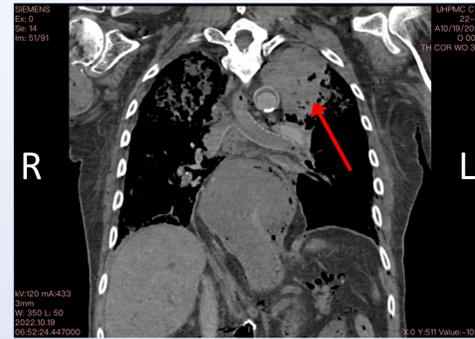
CT coronal view depicting tumor in apex of left lung (red arrow)
